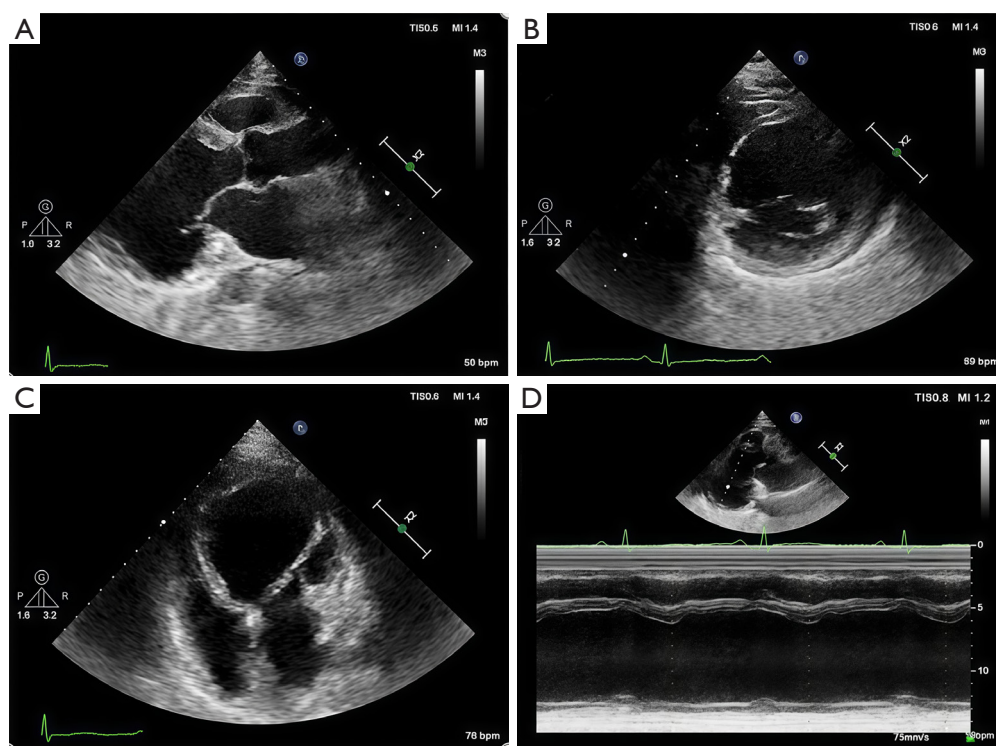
TTE findings. (A) Long-axis left ventricular outflow view; (B) short-axis left ventricular view; (C) four-chamber view; (D) long-axis M mode TTE. TTE, transthoracic echocardiogram.
